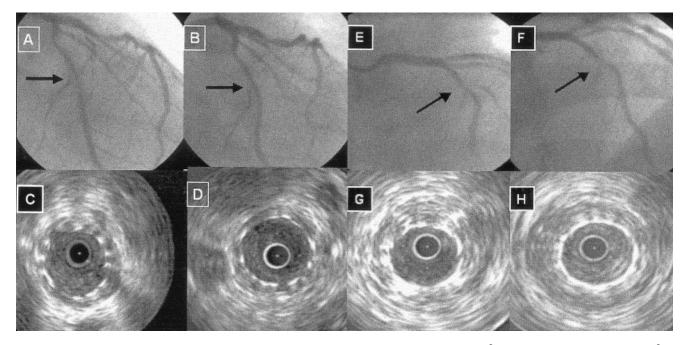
Typical examples of decreases (A–D) and increases (E–H) in mean IH CSA at 24 months. A and E, and B and F were 6- and 24-month follow-up angiographic findings, respectively. C and G, and D and H were 6- and 24-month follow-up intravascular ultrasound findings, respectively. Minimal
